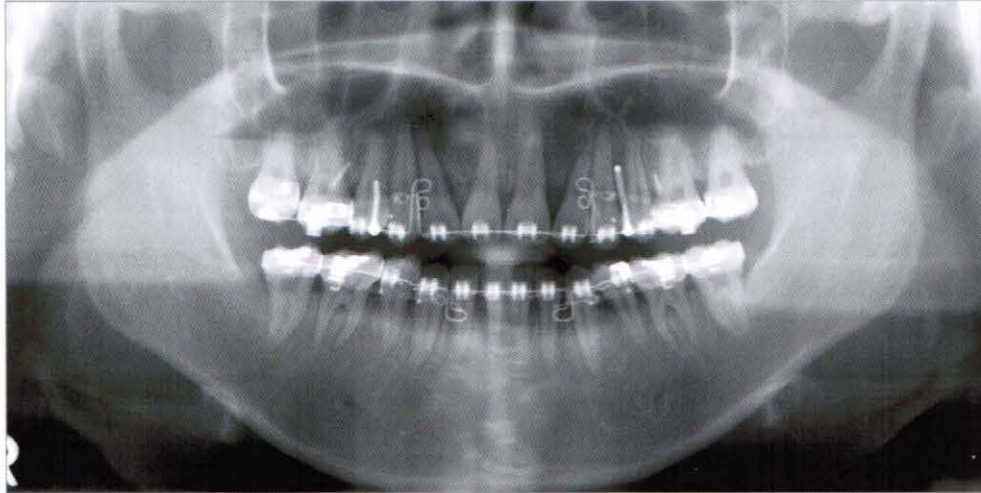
Panoramic radiograph after space closure
